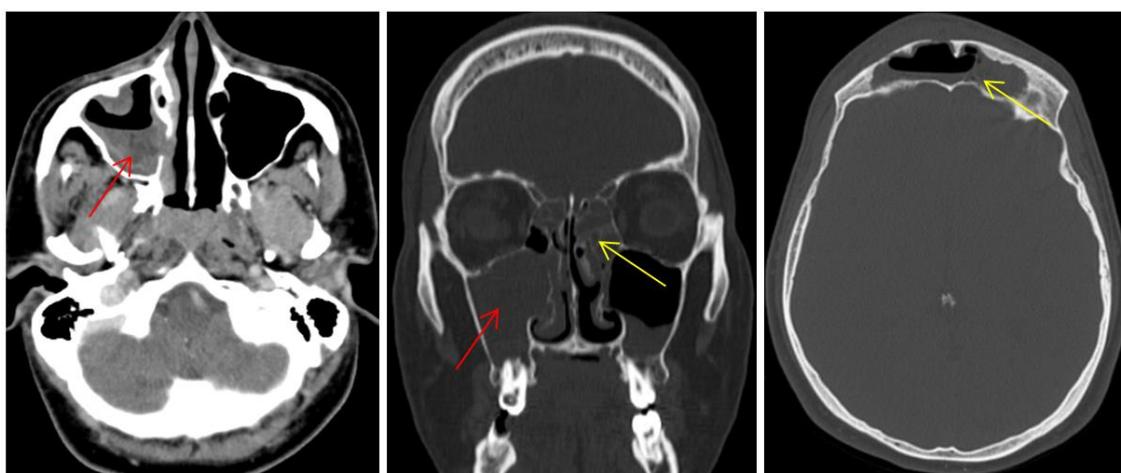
Craniofacial CT in axial (A) and sagittal (B) sections: the presence of right maxillary sinusitis (red arrow) and bilateral fronto-ethmoidal sinusitis (yellow arrow)
